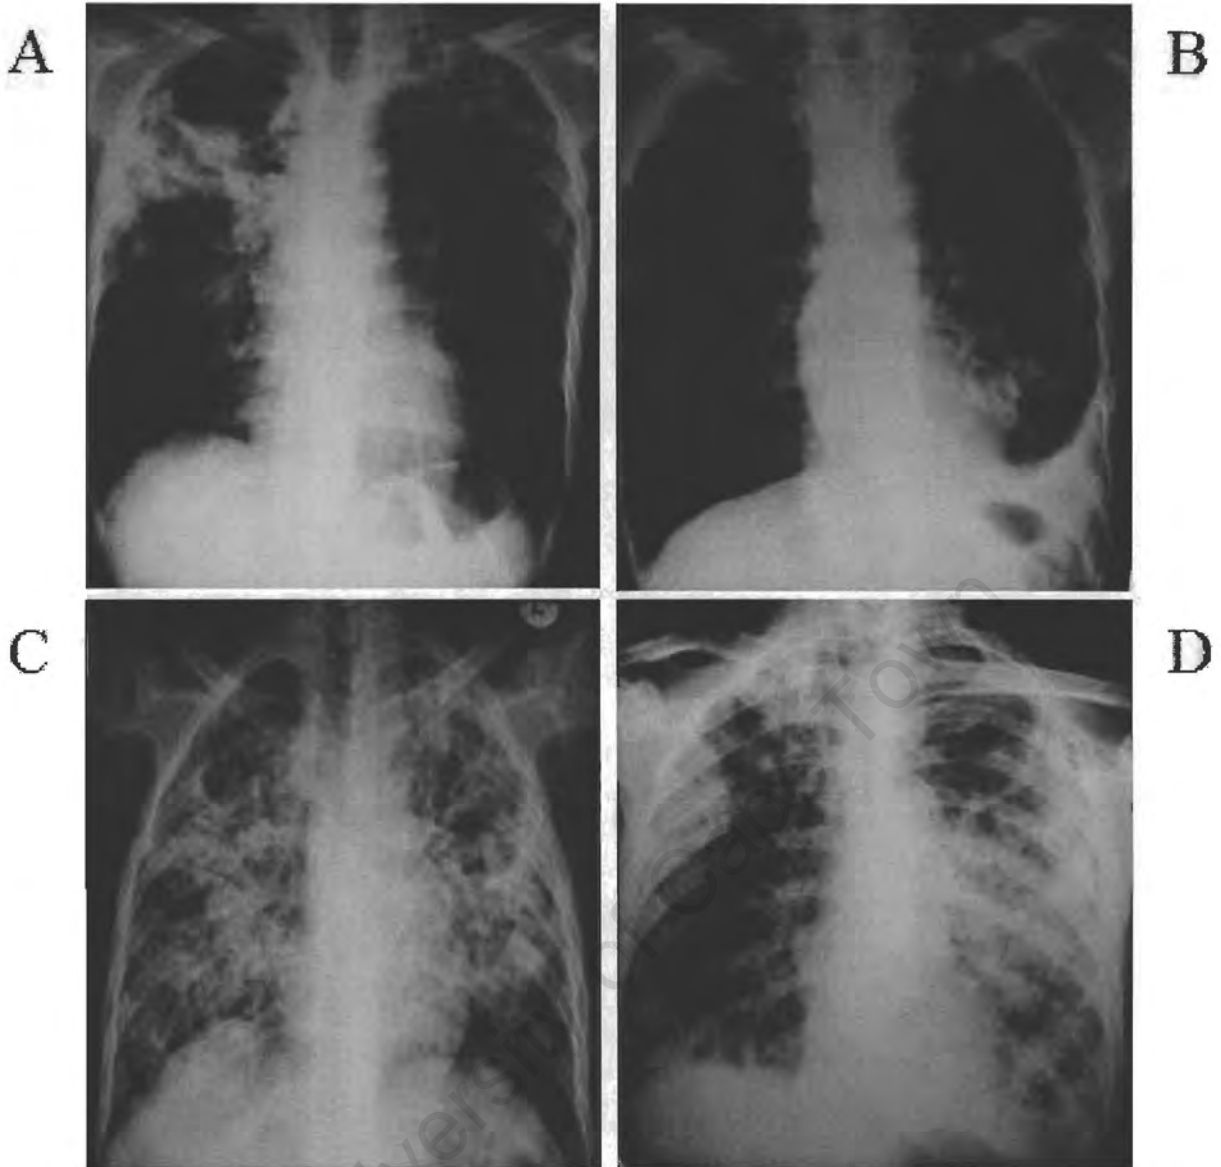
Examples of pre-treatment chest radiographs of patients classified as having limited (A, B) or extensive (C, D) tuberculosis disease.
